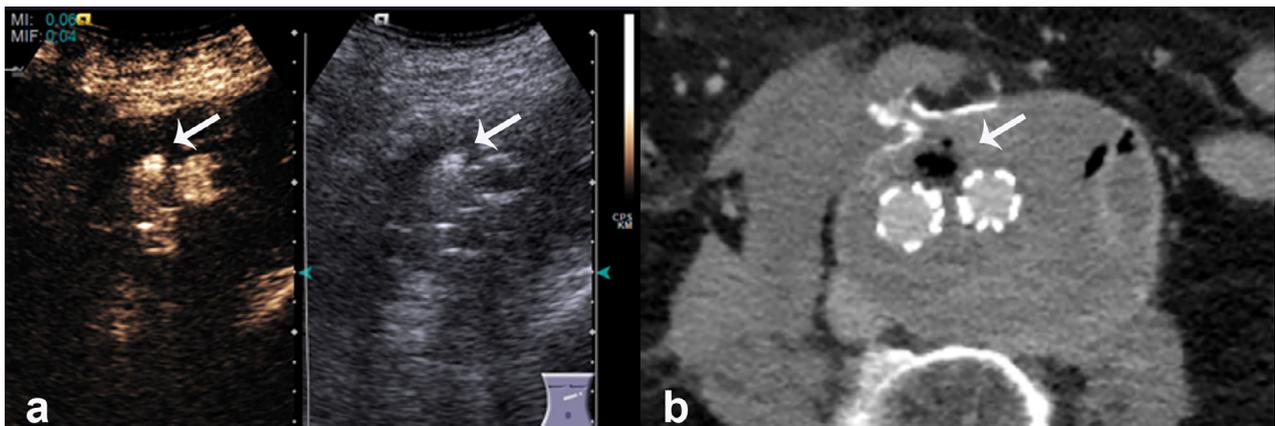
False positive: Post-interventional gas. (a) Cross-section of an aneurysm sac in a contrast-enhanced ultrasound image revealing a hyperechoic lesion (arrow) located ventrally between two stent branches. The lesion is also visible as a hyperechoic structure in corresponding B-mode sonography or contrast mode before intravenous contrast agent injection. (b) Computed tomography angiography confirms post-interventional gas bubbles (arrow) and inhomogeneous thrombosis of the aneurysm sac in a corresponding location.
